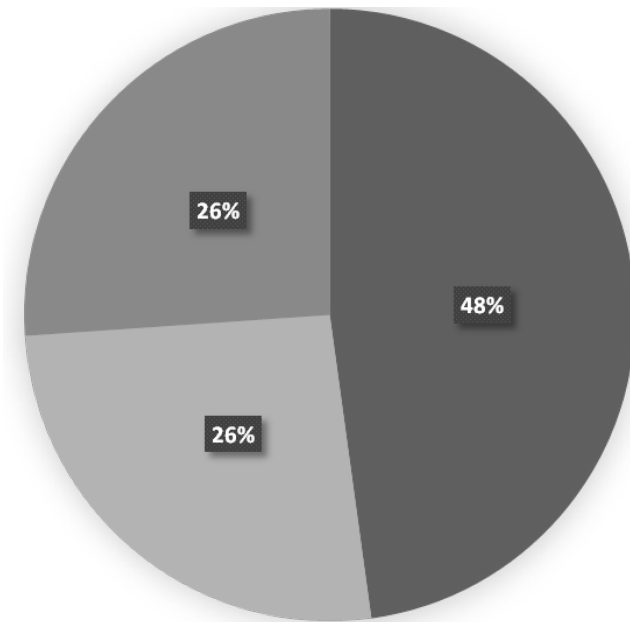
Distribution of chronic subdural hematoma according to their CT appearance.
